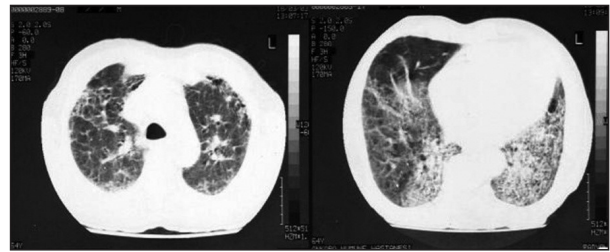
HRCT imaging of the patient; reticulonodular infiltration areas, diffuse nodulations, peribronchial thickenings and ill defined areas of ground glass opacities.
